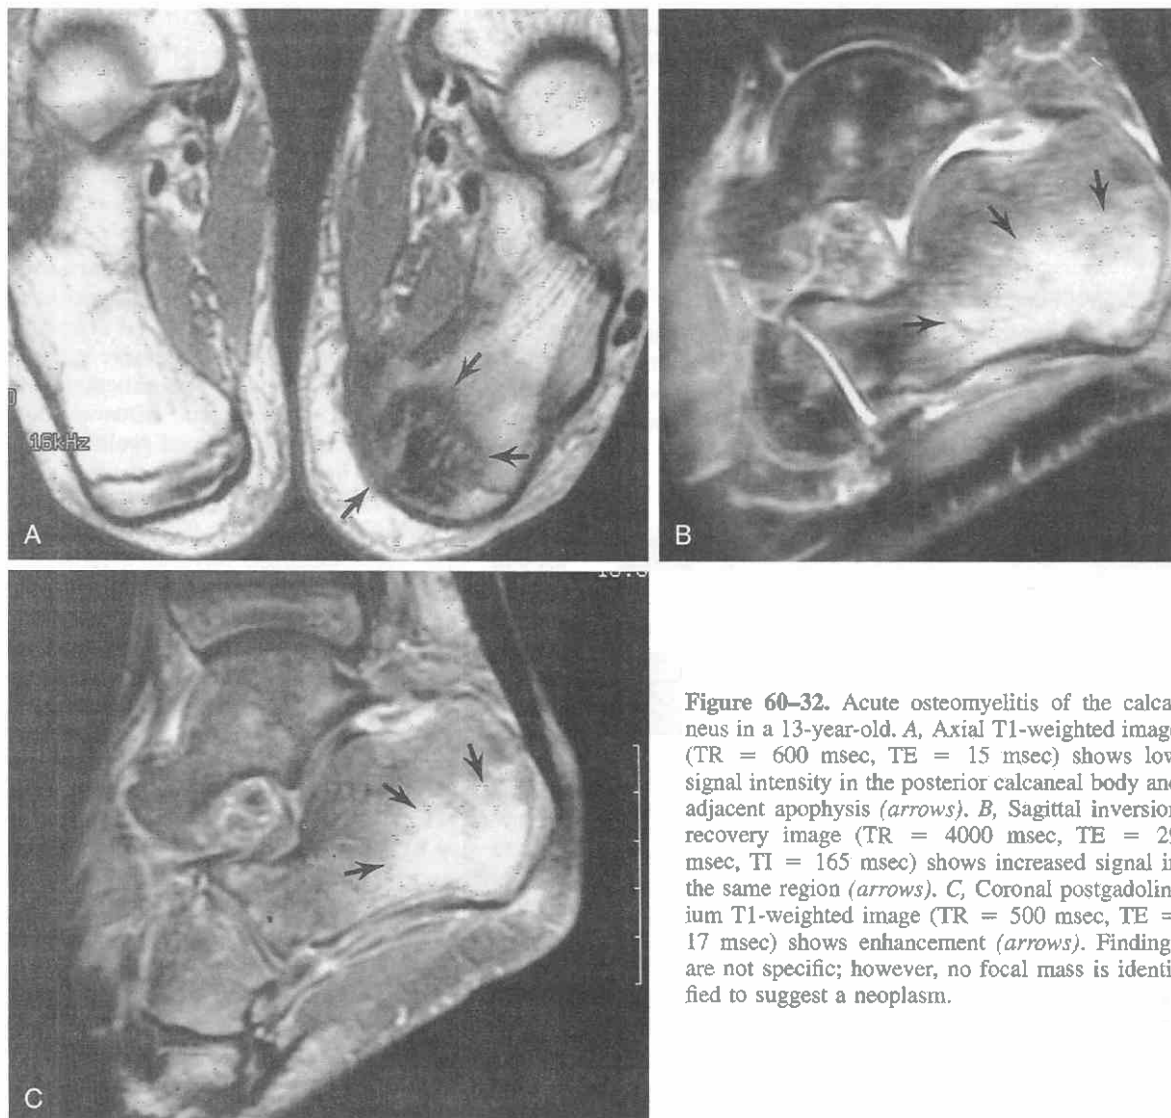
Acute osteomyelitis of the calcaneus in a 13-year-old. *A*, Axial T1-weighted image (TR = 600 msec, TE = 15 msec) shows low signal intensity in the posterior calcaneal body and adjacent apophysis (arrows). *B*, Sagittal inversion recovery image (TR = 4000 msec, TE = 29 msec, TI = 165 msec) shows increased signal in the same region (arrows). *C*, Coronal postgadolinium T1-weighted image (TR = 500 msec, TE = 17 msec) shows enhancement (arrows). Findings are not specific; however, no focal mass is identified to suggest a neoplasm.
